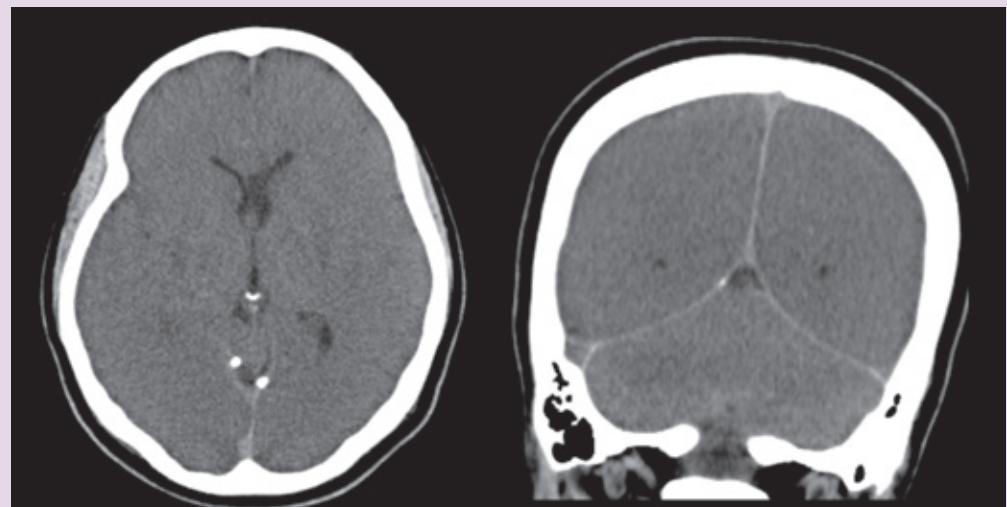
Axial and coronal sections from the initial CT show diffuse cerebral oedema with diffuse loss of grey-white matter differentiation. In addition, there are hypodensities in the basal ganglia bilaterally. The coronal view demonstrates the cerebellar involvement and relative hyperdensity of the falx and tentorium.
